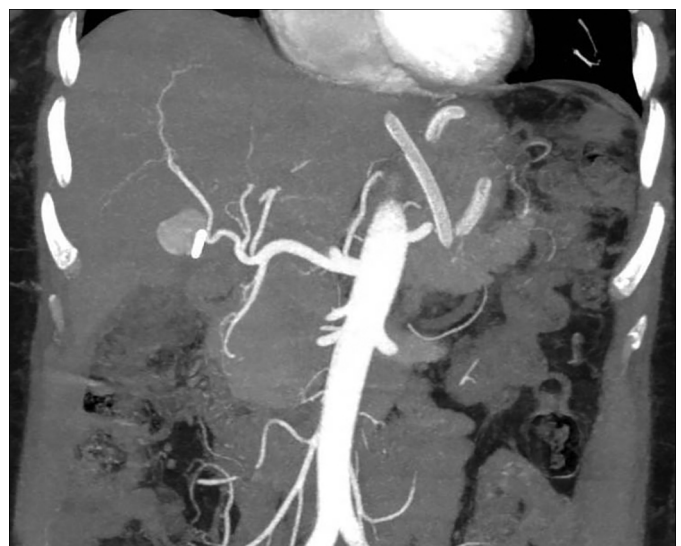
Coronal section of computed tomography angiography showing the pseudoaneurysm from right hepatic artery.
